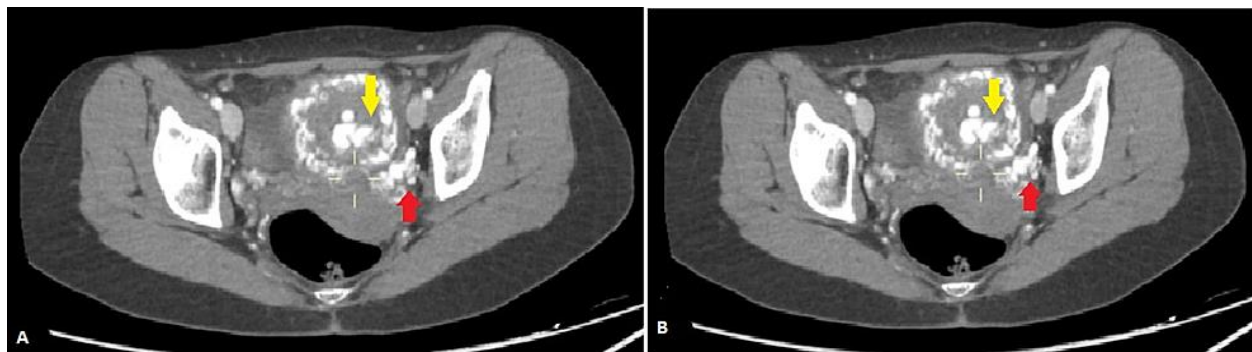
(A and B) CT Vascular angiography, arterial phase image of a 28-year-old female, showing large tuft of vessels within the posterior aspect of the endometrial cavity (red arrow), with extensive collateral in the myometrium, suggesting AVM/AVF with nidus (yellow arrow).
